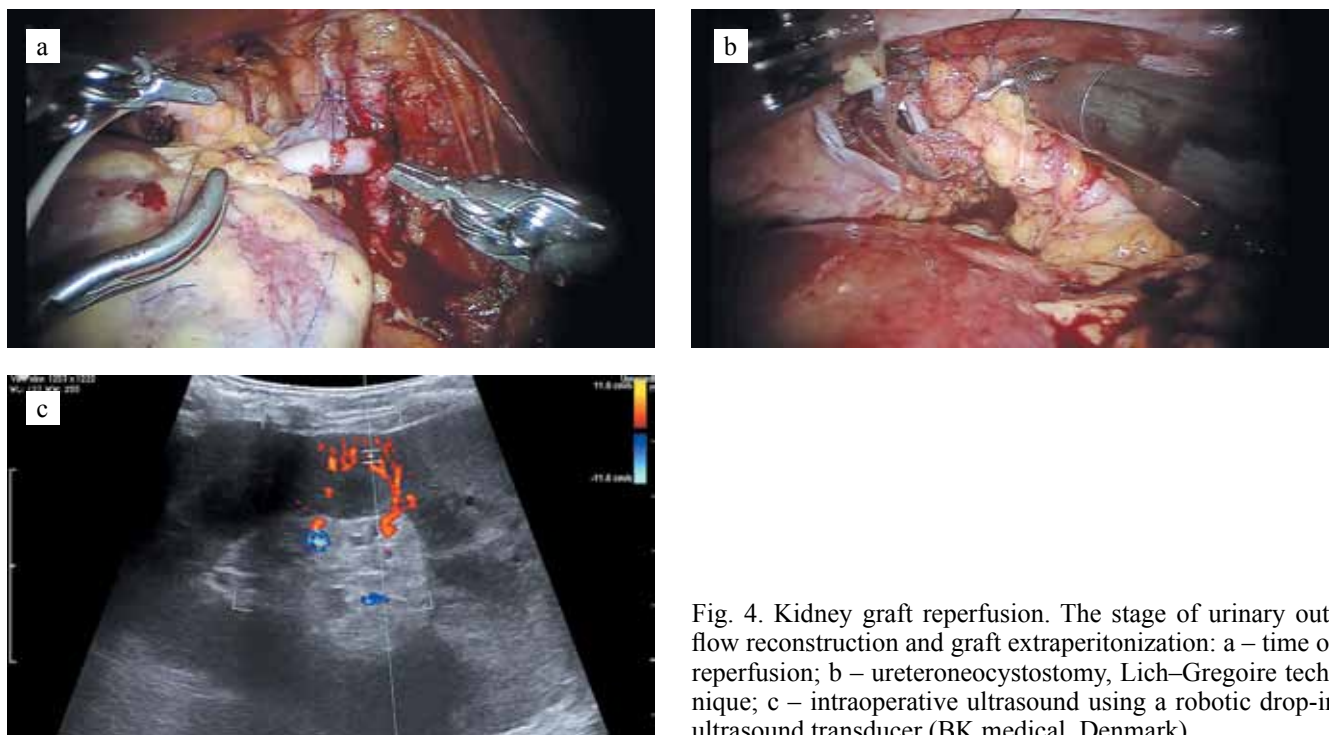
Kidney graft reperfusion. The stage of urinary out-flow reconstruction and graft extraperitonization: a – time of reperfusion; b – ureteroneocystostomy, Lich-Gregoire technique; c – intraoperative ultrasound using a robotic drop-in ultrasound transducer (BK medical, Denmark)
